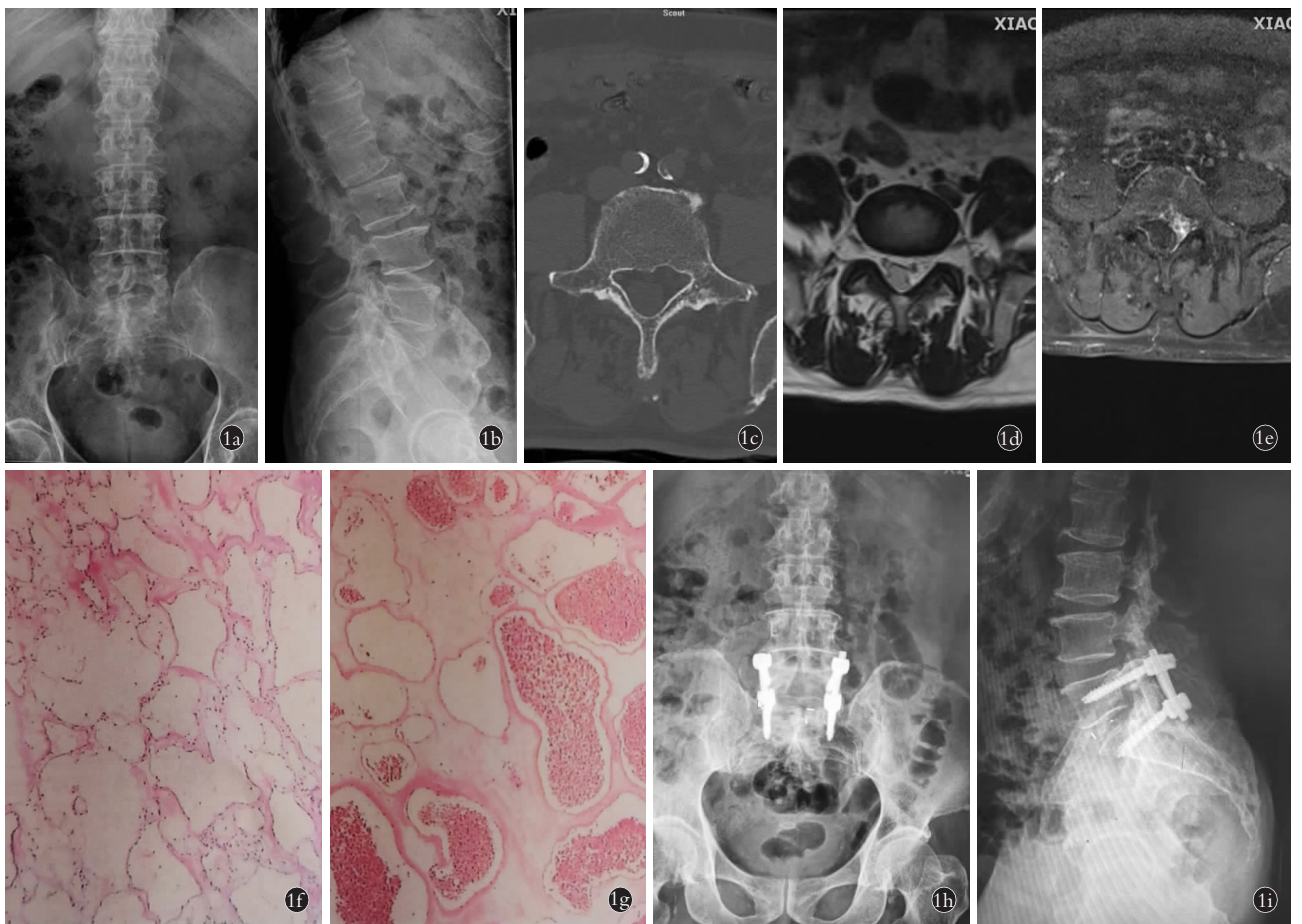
患者,男,72 岁,腰椎椎管内淋巴瘤 1a,1b. 术前腰椎正侧位 X 线片示腰椎退行性变 1c. 术前腰椎 CT 示腰椎退行性改变, 双侧骶髂关节退行性改变 1d. 术前腰椎 MRI 冠状位示腰椎退行性改变, L₂-L₄ 椎间盘稍膨出, 平 L₅ 左侧椎管内可见条索状异常信号影 1e. 术前腰椎 MRI 增强冠状位示 L₅ 平面椎管内硬膜外病变, 脉管性肿瘤, 血管瘤可能性大 1f. 术中快速冰冻活检示腰椎椎管内血管淋巴瘤(HE×100) 1g. 术后病检示腰椎椎管内血管淋巴瘤(HE×100) 1h,1i. 术后 1 周腰椎正侧位 X 线片示内固定在位, 未见松动
